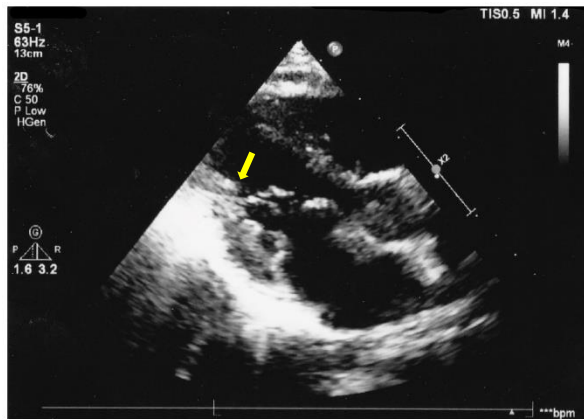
Transthoracic echocardiography showing chordae tendineae of the mitral valve attached to only one papillary muscle (yellow arrow) on the wall of the left ventricle
